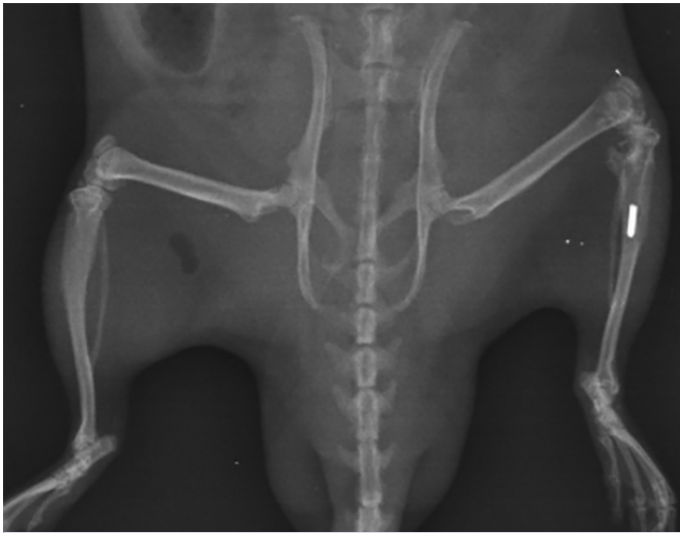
Radiological appearance of bilateral lateral tibia on 30-day radiograph. An intramedullary implant and osteomyelitis are visualized in the proximal tibia on the left side.
